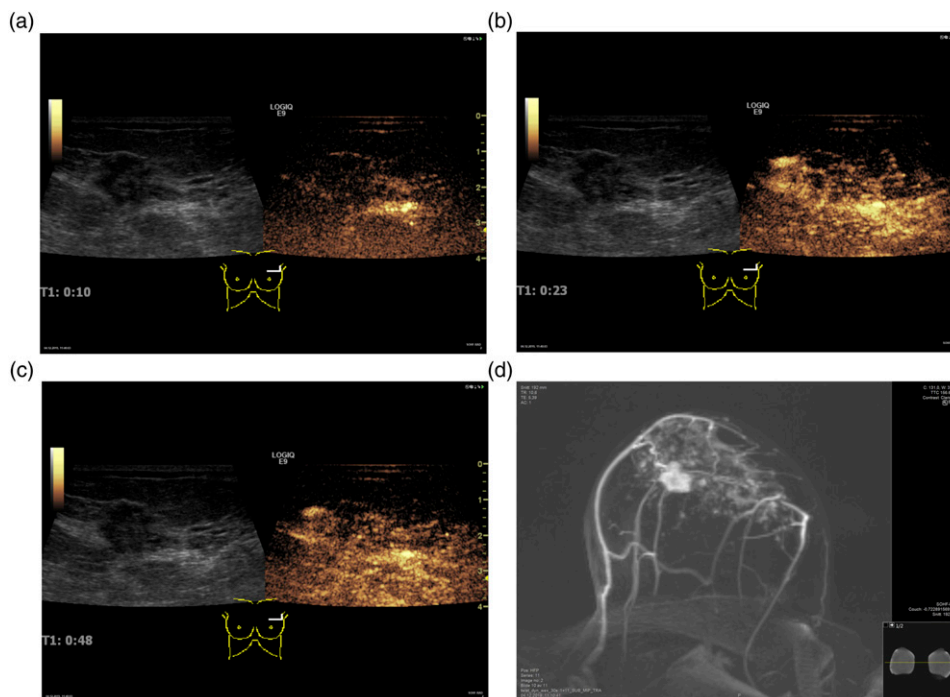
Contrast-enhanced ultrasound demonstrates a peripheral enhancing lesion with penetrating vessels after 10 (a), 23 (b), and 48 s (c). Corresponding magnetic resonance imaging (MIP) (d).
